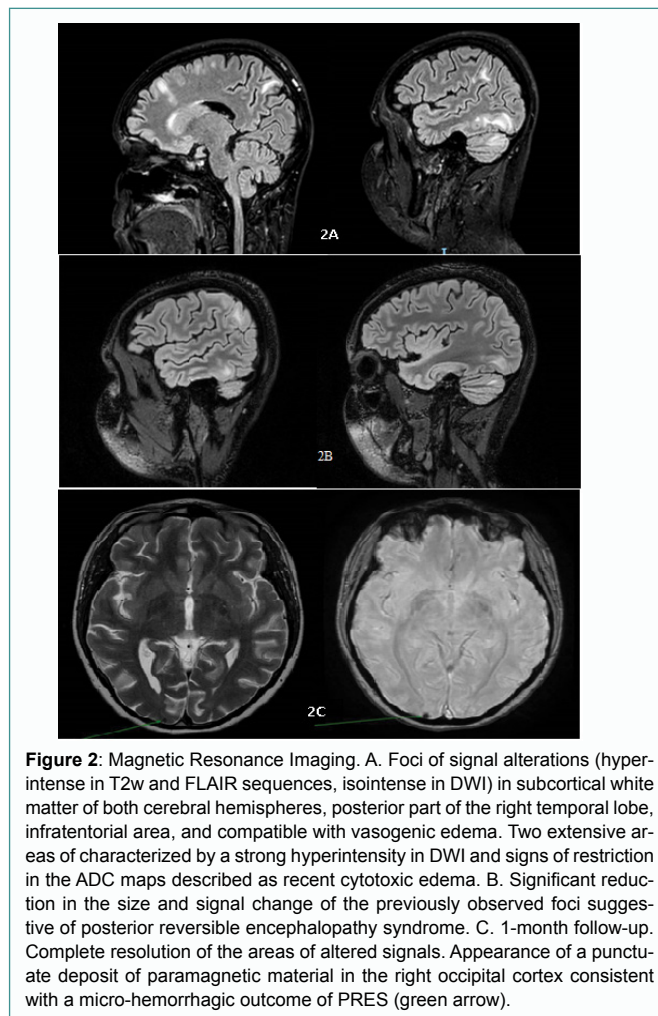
Magnetic Resonance Imaging. A. Foci of signal alterations (hyperintense in T2w and FLAIR sequences, isointense in DWI) in subcortical white matter of both cerebral hemispheres, posterior part of the right temporal lobe, infratentorial area, and compatible with vasogenic edema. Two extensive areas of characterized by a strong hyperintensity in DWI and signs of restriction in the ADC maps described as recent cytotoxic edema. B. Significant reduction in the size and signal change of the previously observed foci suggestive of posterior reversible encephalopathy syndrome. C. 1-month follow-up. Complete resolution of the areas of altered signals. Appearance of a punctuate deposit of paramagnetic material in the right occipital cortex consistent with a micro-hemorrhagic outcome of PRES (green arrow).
